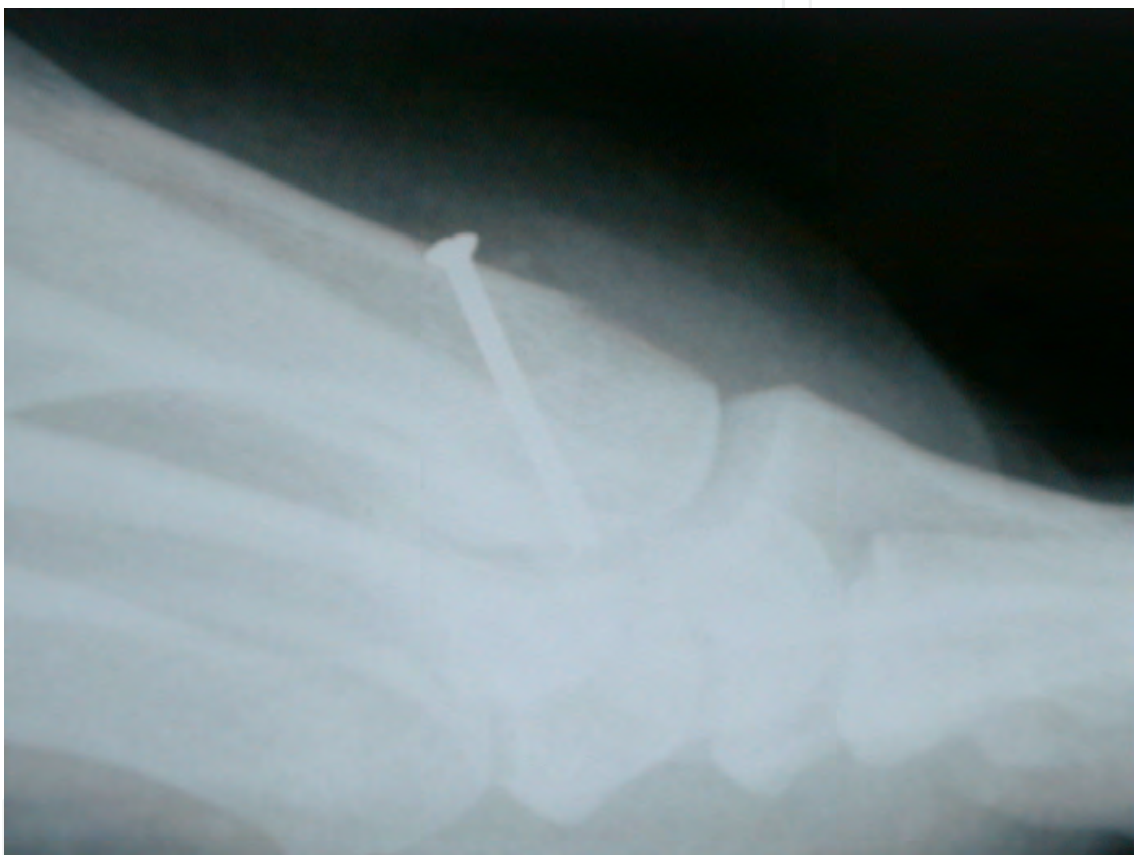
Lateral radiographic image of the same patient revealing resection of the osteophyte from the dorsal first metatarsal. The increase in joint space can be appreciated in this image as well. Fixation of the osteotomy was provided with a single 3.0 mm short thread cortical screw.
